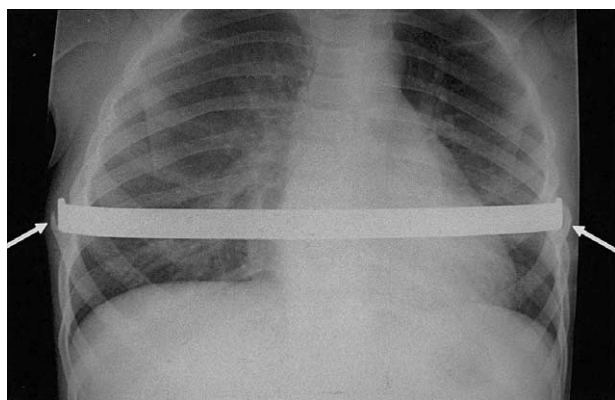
Chest radiograph shows a minimally invasive pectus bar that has been in place for 2 years. Note the bone formation around the ends of the bar bilaterally.
